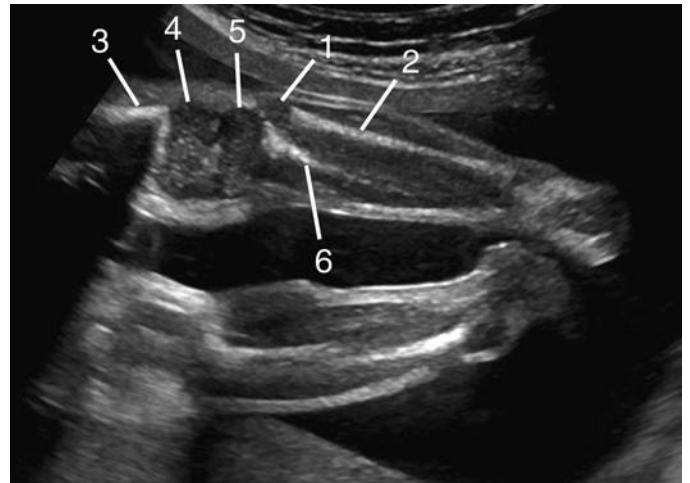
Coronal sonograms of the knee. 1, proximal fibular epiphysis; 2, fibular diaphysis; 3, femoral metaphysis; 4, lateral femoral condyle; 5, proximal tibial epiphysis; 6, tibial diaphysis.
